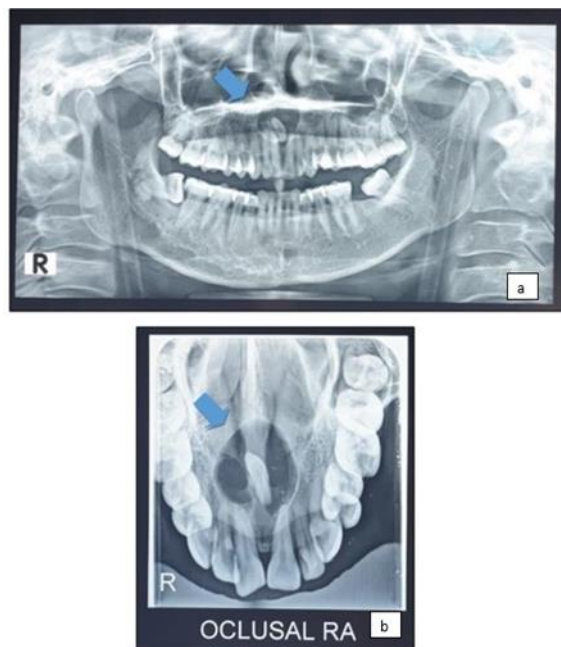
Orthopantomogram Radiographic Imaging (a) Occlusal Radiographic Imaging (b)
